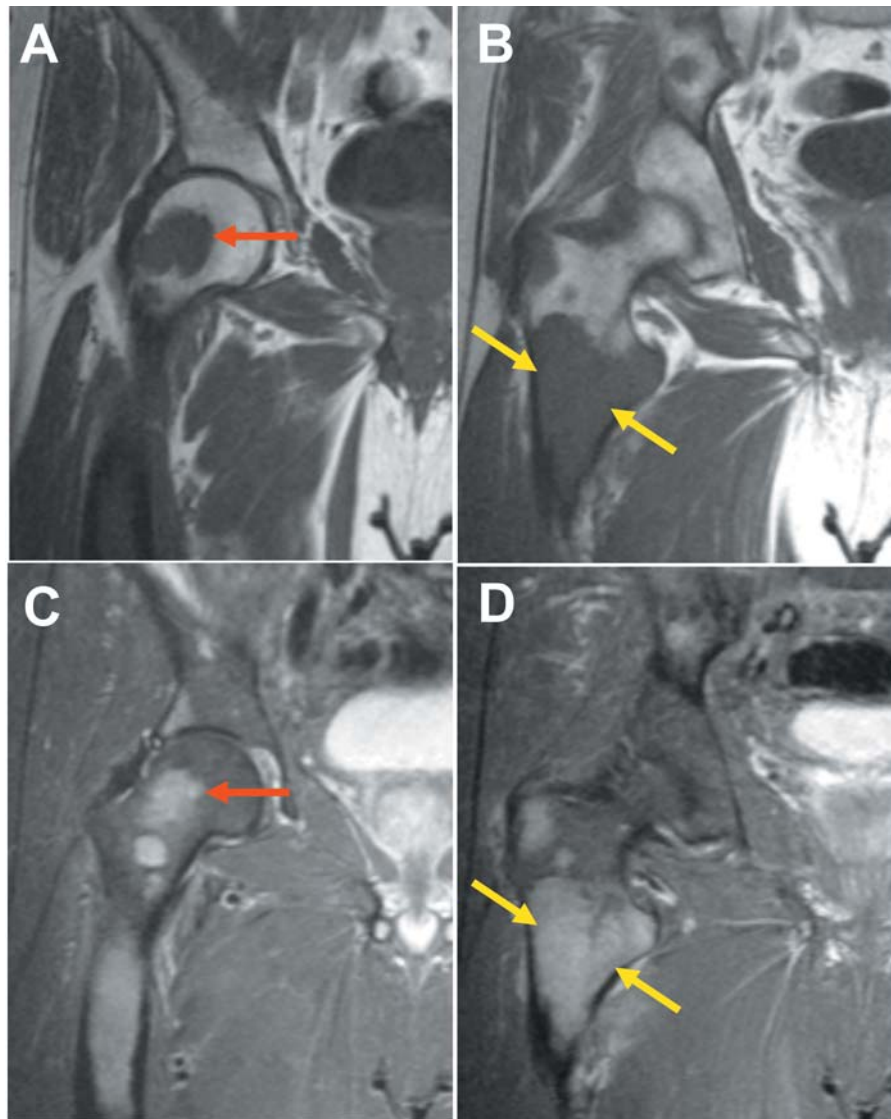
Standard T1-weighted (A,B) and T2-weighted (C,D) MRI sequences showing osteolytic lesions and dense bone marrow infiltration very distinctly. Compare with plain x-ray taken 3 days later (Figure 1C).
